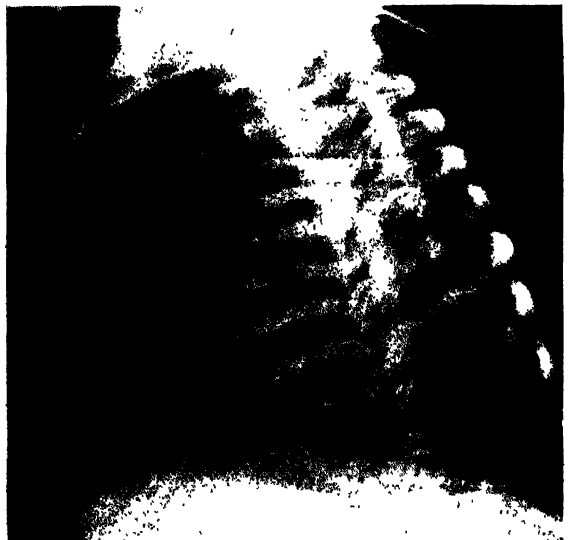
Case 10. Lateral radiograph. Transradiant avascular region lies in anterior half and is sharply demarcated by compressed lung posteriorly. See also Figs. 46, 48, 49 and 50.
